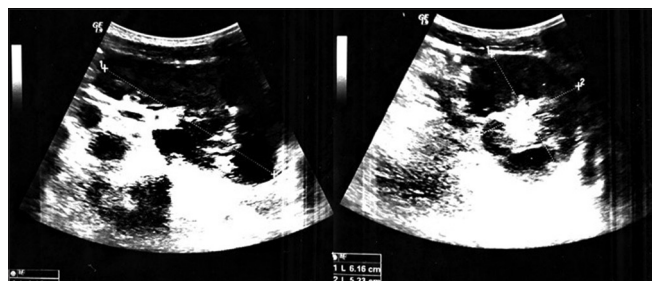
Renal ultrasonography demonstrating of the left kidney
